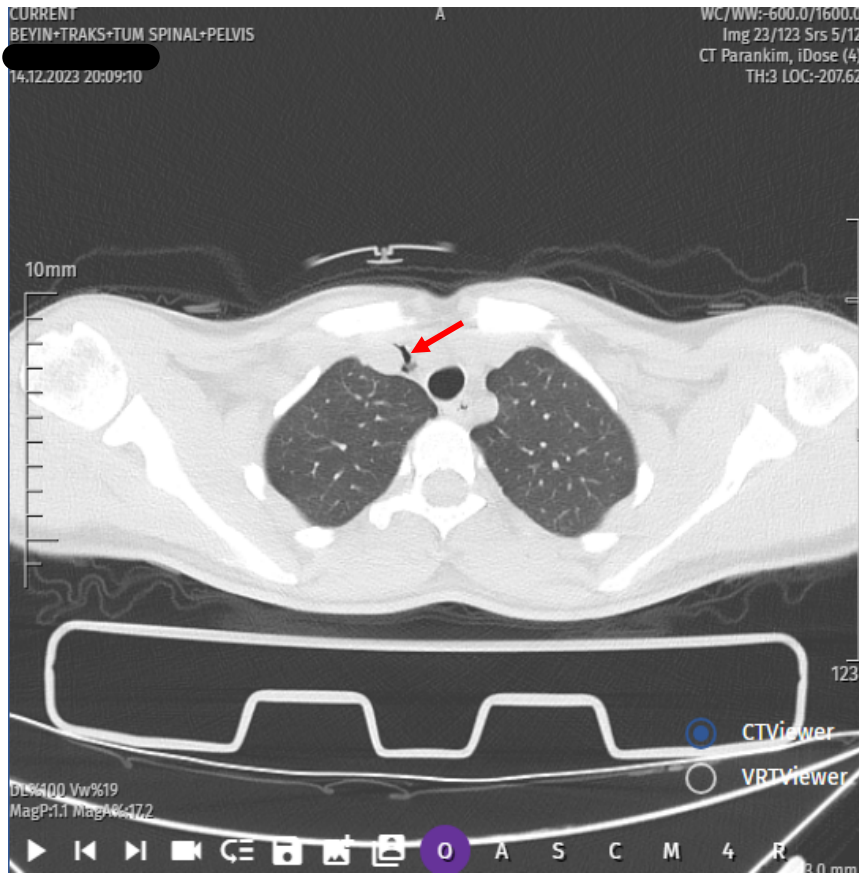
CT image of the patient.
